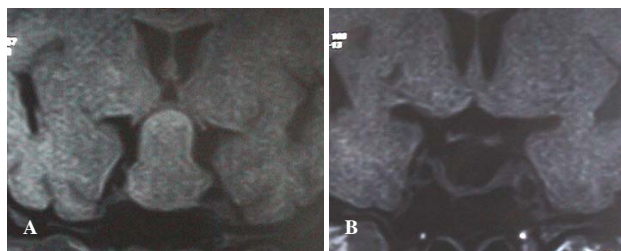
MRI of head coronal section showing huge pituitary tumor with suprasellar (Hardy's B) and parasellar extension (Knosp 2). A. Pre operative MRI. B. Post operative MRI showing complete resection.
